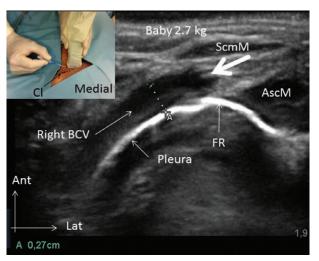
Ultrasonographic view of the entire long-axis of the right BCV in a 2.7-kg infant. *Small picture*: ultrasound probe placed in the right supraclavicular region so as to obtain the optimum long-axis view of the right BCV, iv cannula indicating the direction of cannula insertion. *Ultrasound image: white, boldfaced arrow* indicates iv cannula entry. A indicates diameter of the BCV, 2.7 mm. Ant = anterior; AscM = anterior scalene muscle; BCV = brachiocephalic vein; CI = clavicle; FR = first rib; Lat = lateral; ScmM = sternocleidomastoid muscle.
